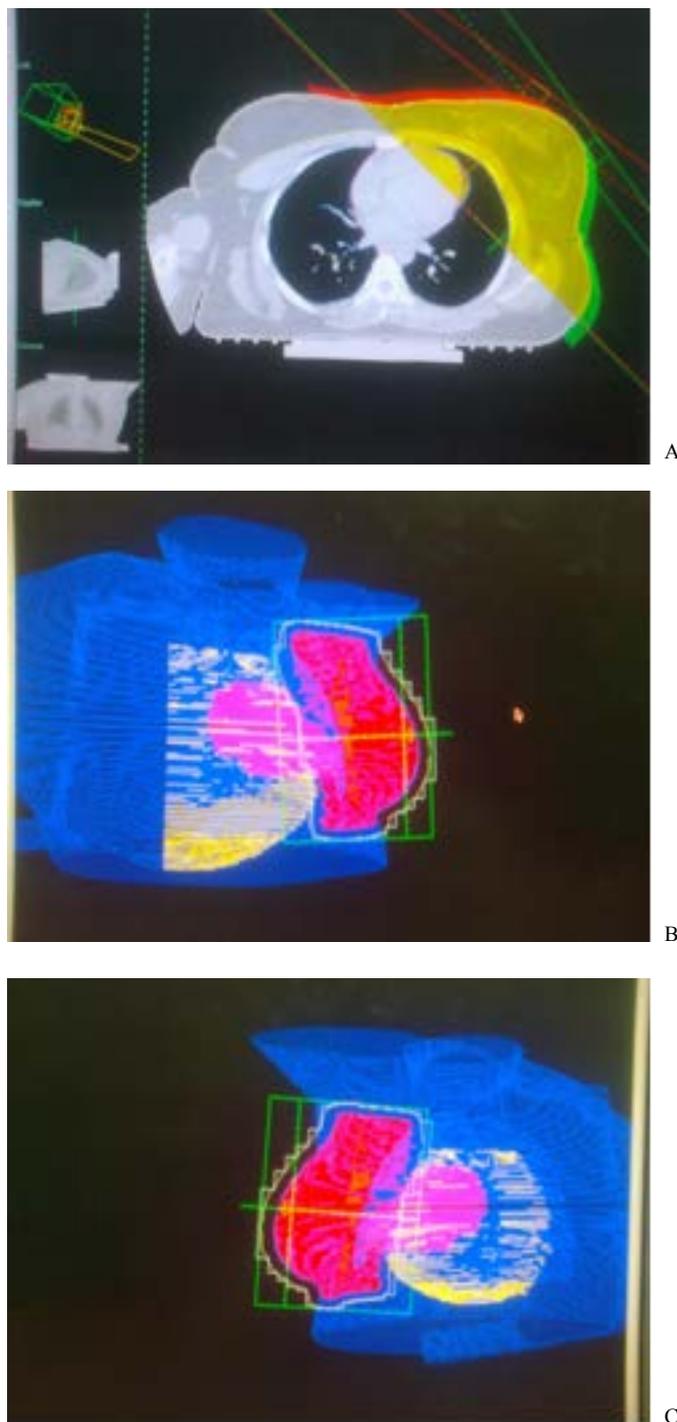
CT axial slices (A) and REV (B & C) show medial and lateral tangential fields of 3DCRT.
